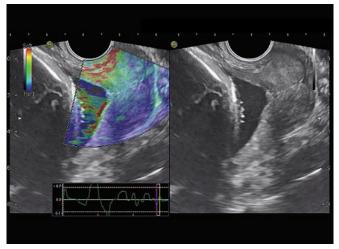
Transvaginal ultrasonographic B-mode and elastographic images of the cervix of a pregnant woman. Anterior parts of the cervix, which are subjected to a greater degree of pressure by the transducer, appear to be softer than the posterior parts, which are further away from the pressure. The colors seem to be merely a reflection of the degree of force applied by the transducer
